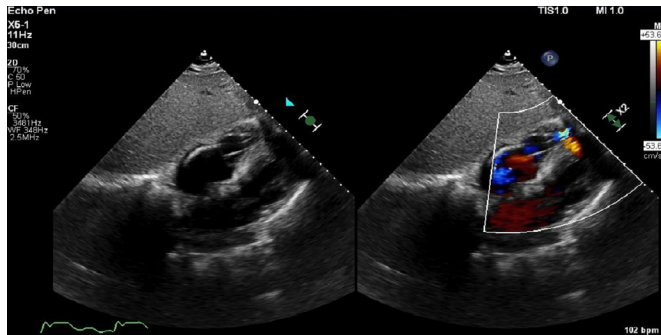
Transthoracic echocardiogram shows the ventricular septal rupture (white arrow) in subcostal view.
